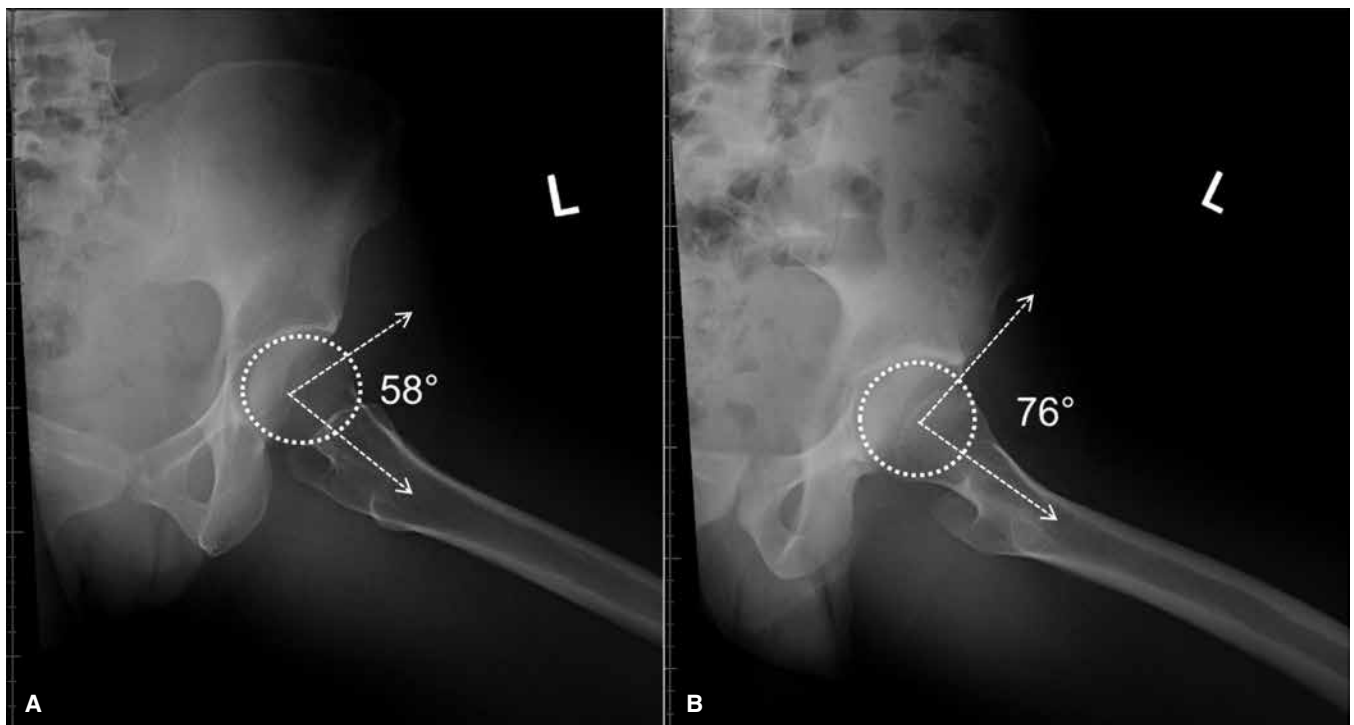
Left Frog-leg lateral view radiographs of 31-year-old female with alpha angle measured at 58 degrees. (B) Left Frog-leg lateral view radiographs of 19-year-old male with alpha angle measured at 76 degrees, revealing asphericity of femoral head and neck and cam type morphology.
